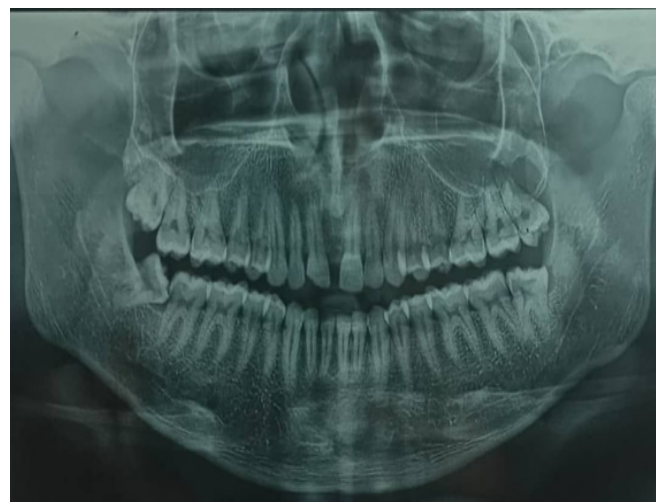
Orthopantomograph showing the extent of the lesion
